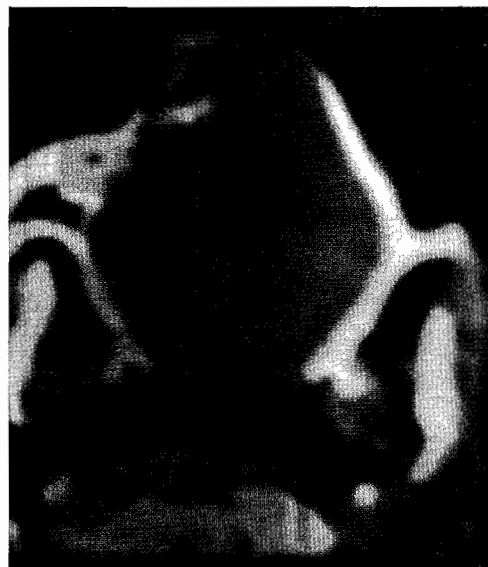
CT Scan axial section (soft tissue window) showing big soft tissue mass occupying whole nasal cavity and extending to nasopharynx
